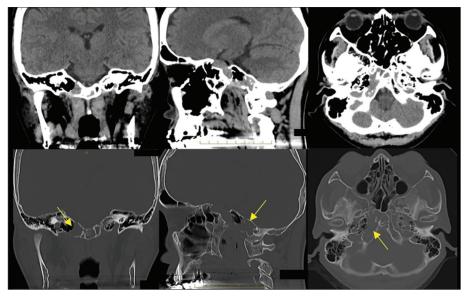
Computed tomography demonstrating the intraosseous mass lesion and bone erosion of the middle and lower clivus, extending laterally to the right occipital condyle (arrows).
